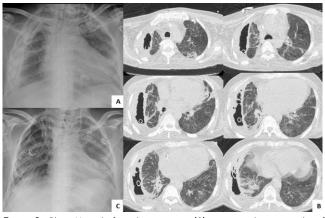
Chest X-ray before decortication (A), computed tomography of thick pleura before decortication (B), chest X-ray after decortication on the first day with three drains in the chest (C)
